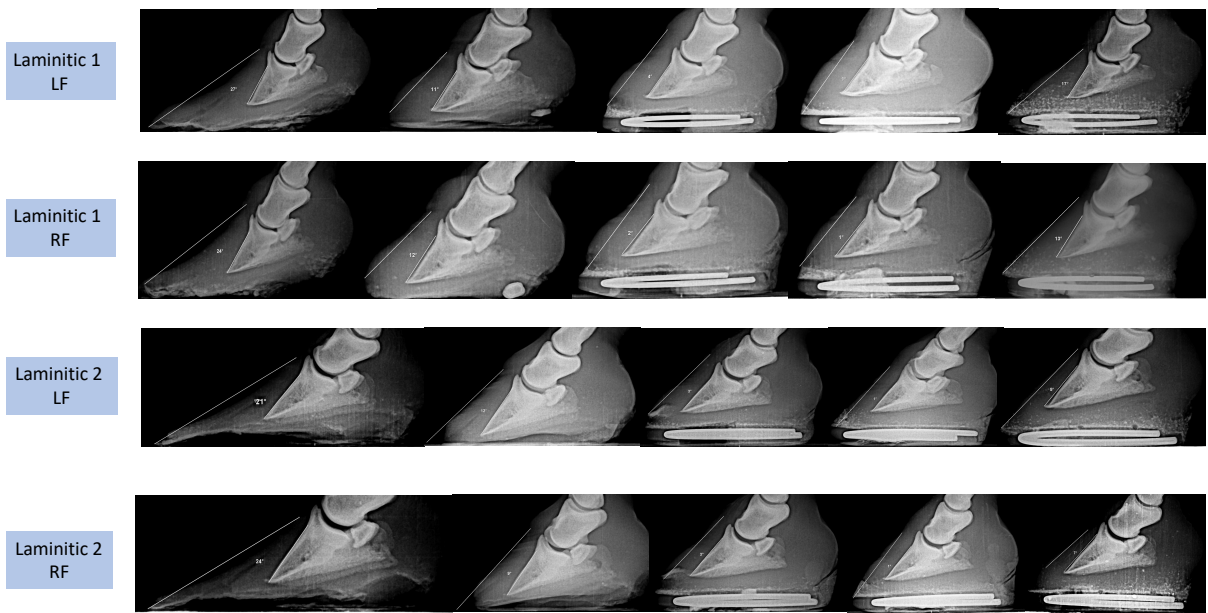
Radiograph images of the left and right forelimbs of the two laminitic equids with rotational measurements. Progressing from day 57 (first trim), 115 (first shoeing), 162 (second shoeing), and (261 final shoeing) from left to right.
